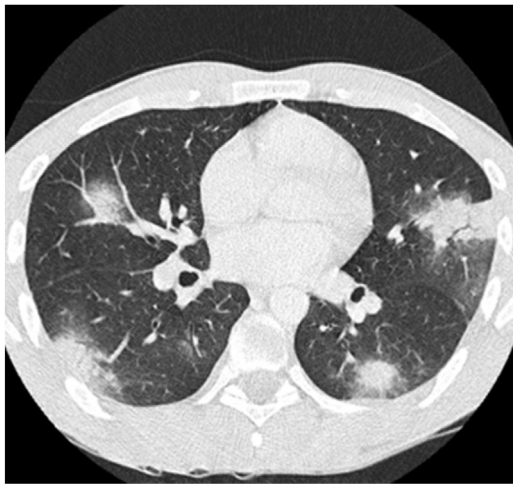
Chest CT showing nodular consolidation in both lungs.
